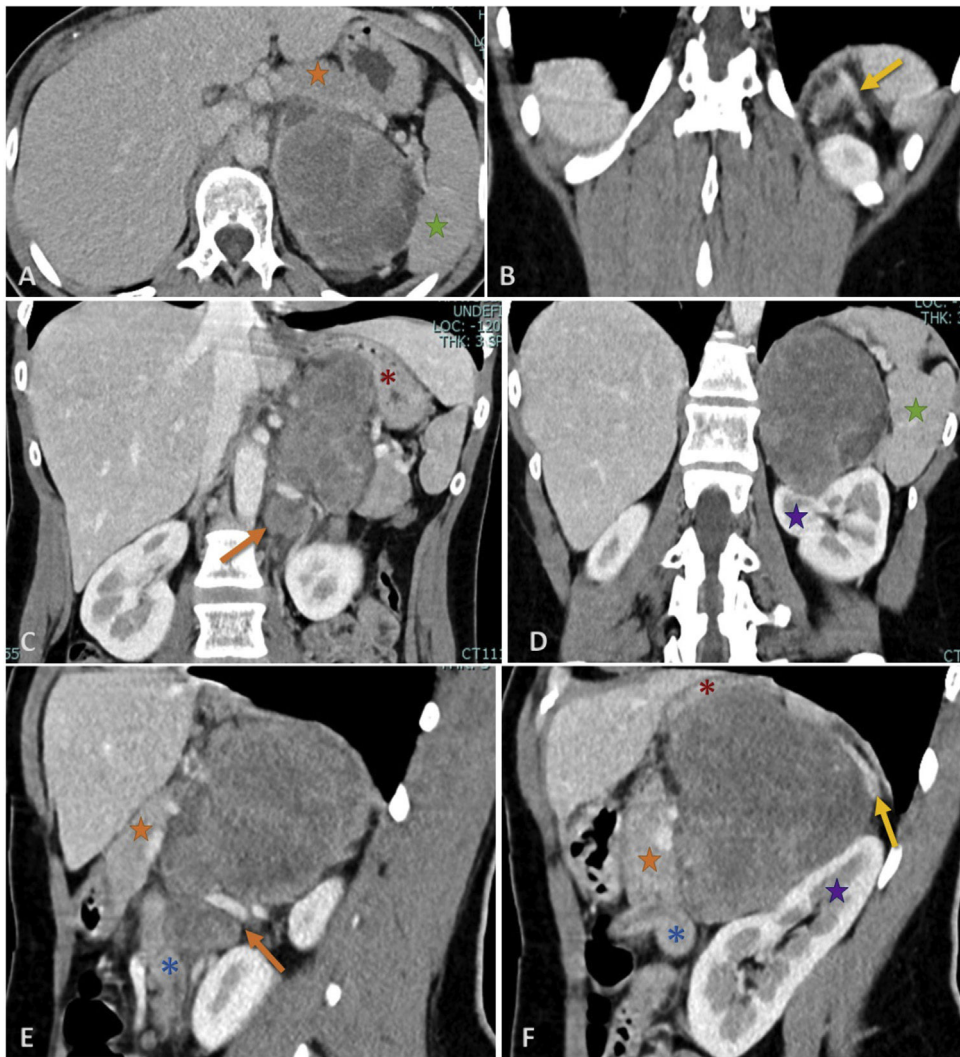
Contrast-enhanced abdominopelvic CT scan, soft tissue window (axial plane – A, coronal reformatted plane – B, C and D, sagittal reformatted plane – E and F) confirms the presence of an heterogeneous enhancing mass in the left upper retroperitoneum, displacing and deforming all adjacent organs (stomach – red asterisk, duodenum – blue asterisk, spleen – green star, pancreas – orange star, adrenal gland – yellow arrow, and kidney – purple star), with loss of fatty plane between these organs and the lesion. There are no clear signs of invasion of adjacent organs, however the mass is seen protruding into the renal sinus (orange arrow).
